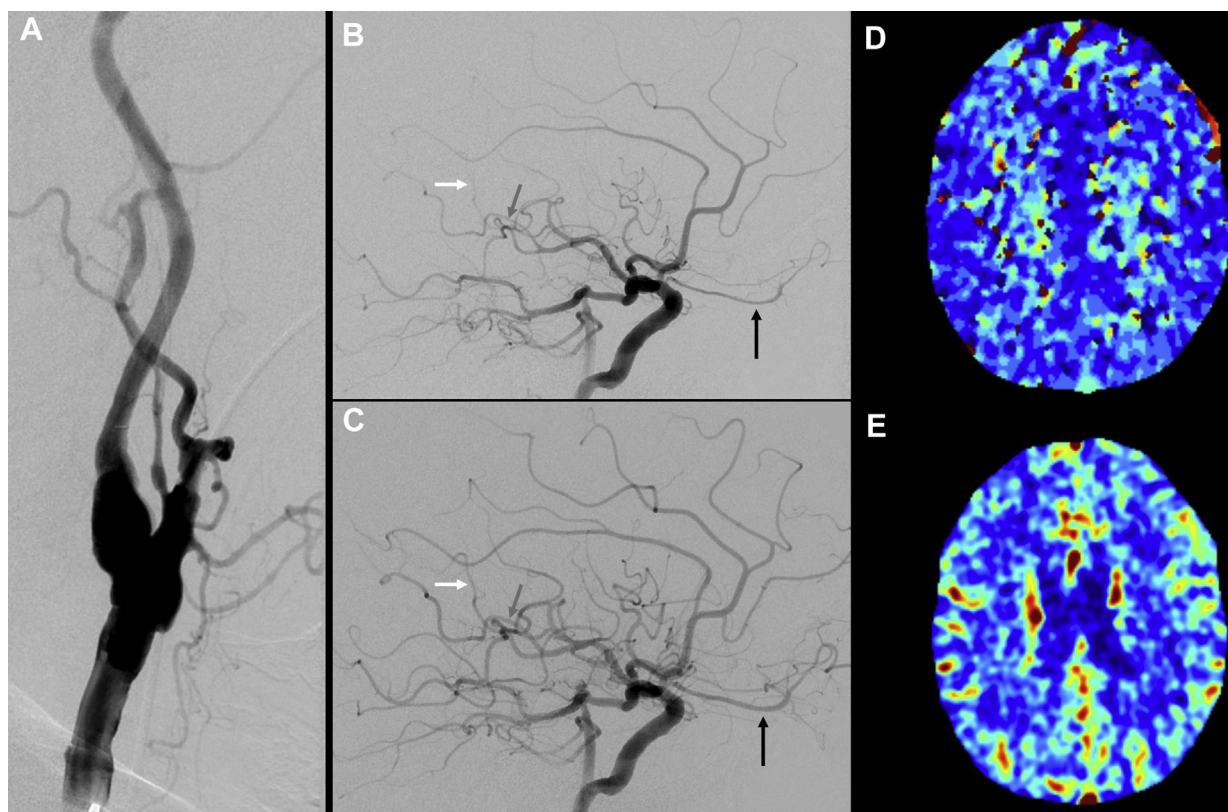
Cerebral angiography was performed because of a suspected diagnosis of reversible cerebral vasoconstriction syndrome (RCVS). At the start of the procedure, a patent right carotid artery bifurcation was visualized (A). A cerebral angiogram revealed narrowing of multiple M2/M3 middle cerebral artery branch vessels (B; *dark gray* and *white arrows*), with narrowing of the ophthalmic artery (*black arrow*) and its branch vessels, which resolved with verapamil administration (C). Postprocedure computed tomography (CT) perfusion imaging showed symmetric mean transit times (D) and cerebral blood volume (E).
